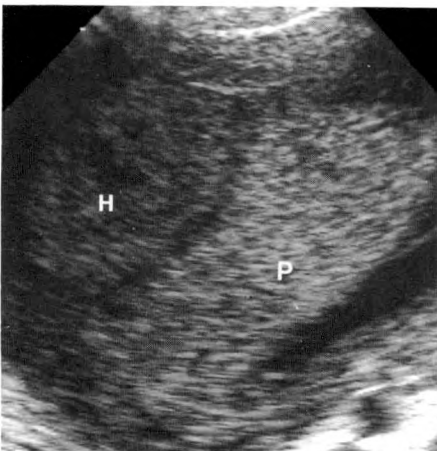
A sonogram made at 13 menstrual weeks shows a large, sonolucent hematoma (H) that is predominantly subchorionic in location. Hematoma extends beneath margin of placenta (arrow), detaching it from adjacent myometrium.
